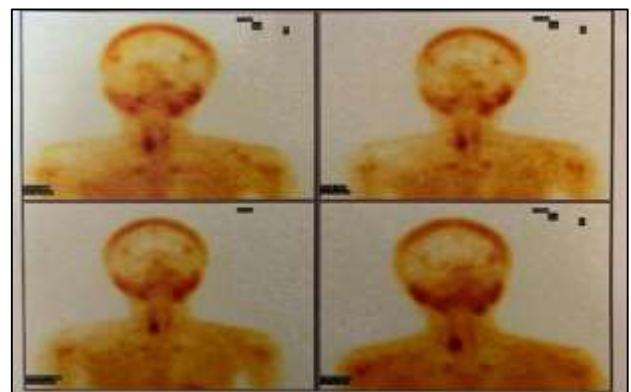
Technetium 99m MIBI scintigraphy showed retention of tracer in relation to right lower lobe of thyroid gland.
